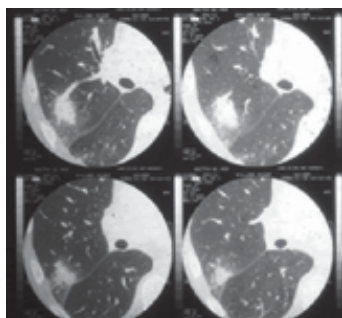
Chest CT shows an irregular airspace opacity in the posterior segment of the right upper lobe (semi-invasive aspergillosis confirmed by FNAC).
